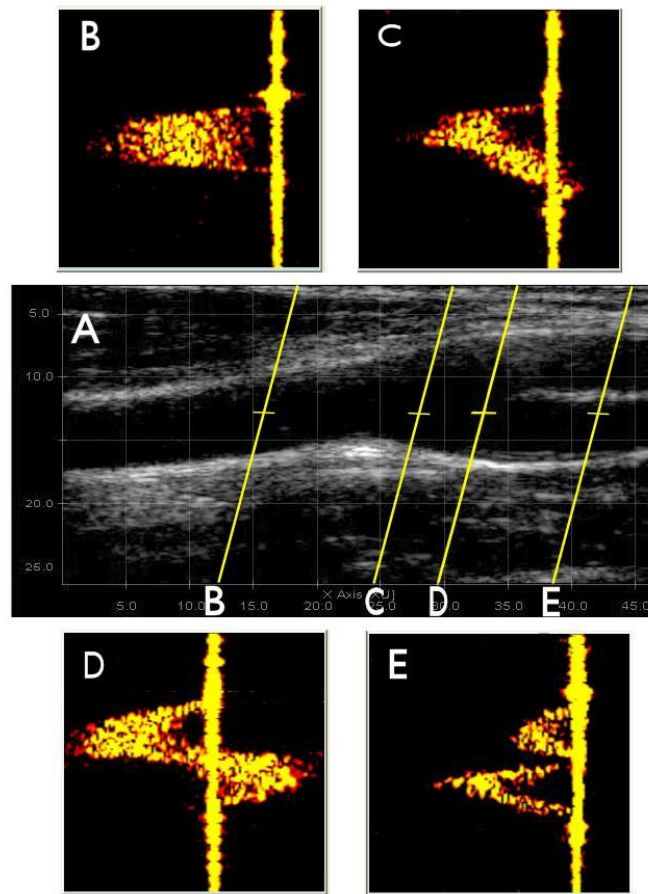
PC-based user interface for Ultrasound Advanced Open Platform instrumentation (Courtesy of Electronics and Telecommunications Dept., Florence University, Italy).
